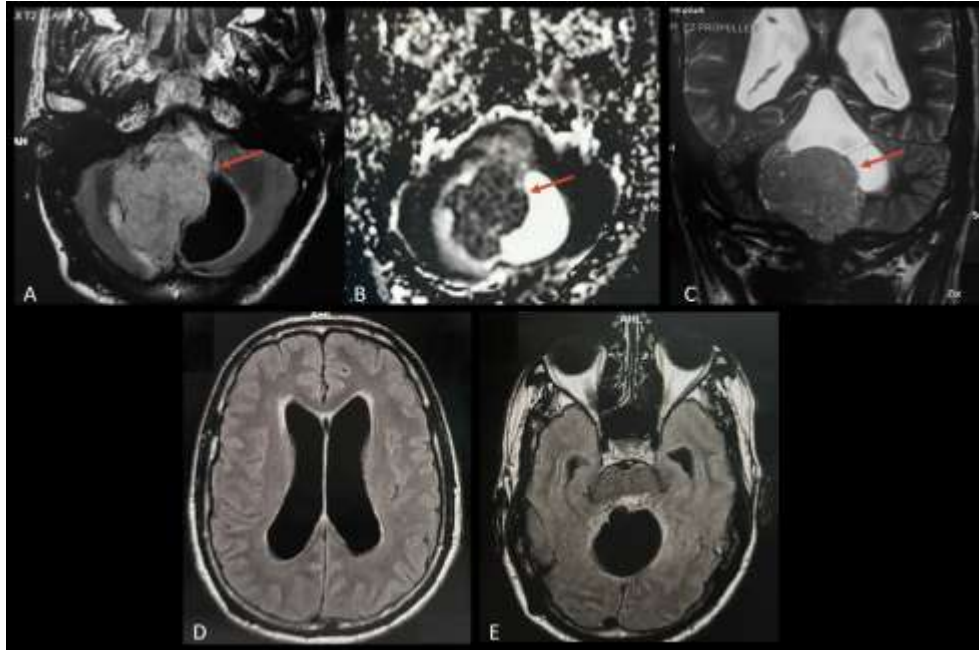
Brain MRI in axial T2 FLAIR (A), axial ADC map (B) and coronal T2WI (C) sequences demonstrated a multilobulated fourth ventricular mass (arrow), and display hyperintense signal on T2WI/FLAIR and low ADC value. This mass caused obstruction leading to hydrocephalus (D, E).
